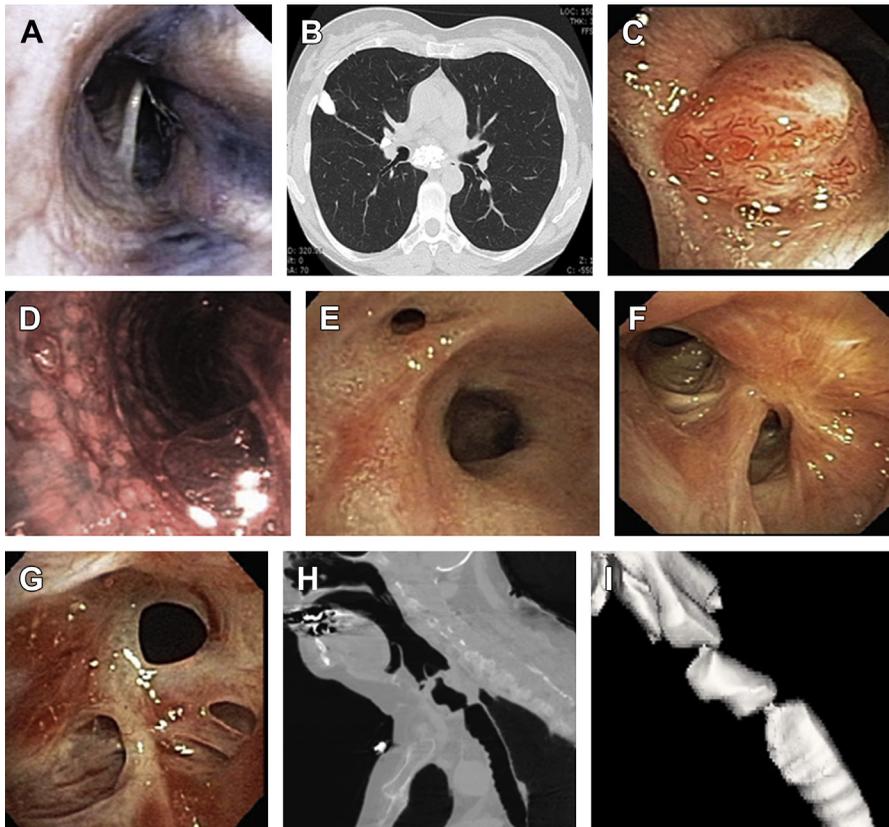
Examples of benign tracheobronchial stenosis. (A) Anthracosis. (B) Broncholithiasis, as shown on CT scanning. (C) Endoscopic image of the adjacent mucosal reaction. (D) Tuberculosis with submucosal granulomas. (E) Bronchial stenosis caused by Wegener granulomatosis. (F) Posttransplant bronchial stenosis. (G) Complex webbed stenosis of unknown cause. (H) Sagittal and (I) three-dimensional reconstruction of focal benign tracheal stenosis.
